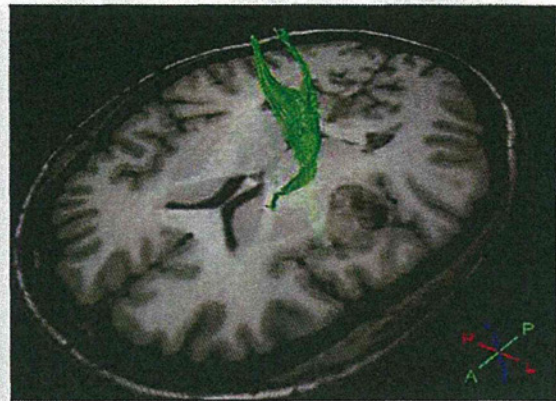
Magnetic resonance image (MRI)-tractography; Pyramidal tract is displaced from the tumor.
